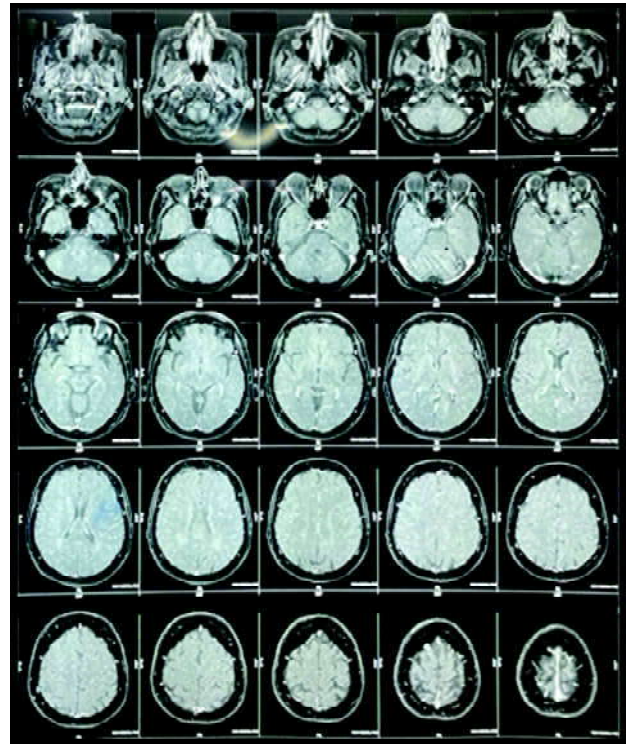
Initial MRI Brain with contrast study.
